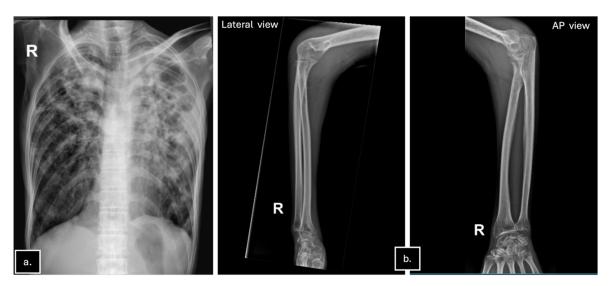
Imaging before treatment (a) Chest X-Ray; (b) X-Ray of right forearm
